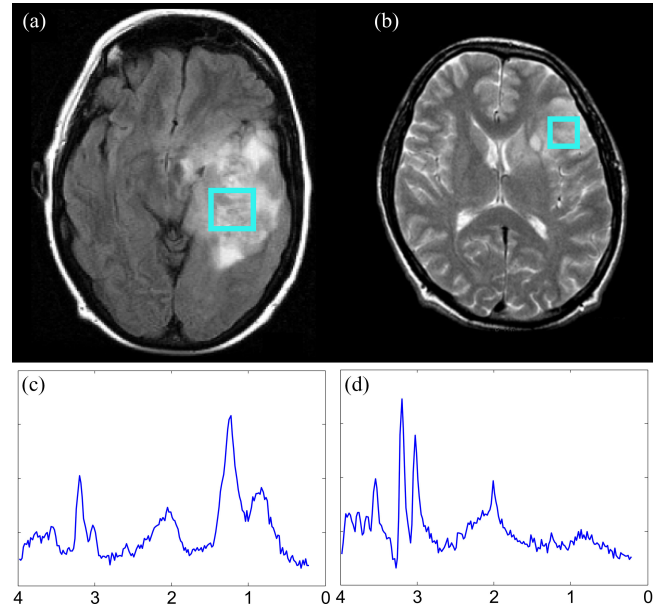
(a) FLAIR image of the misclassified GII case; (b) T2-weighted image of one misclassified GIV case; (c) Blue curve: SV MRS signal of (a); (d) Blue curve: SV MRS signal of (b); Planned SV MRS acquisitions are shown in cyan boxes overlaid on structural MRI images.
